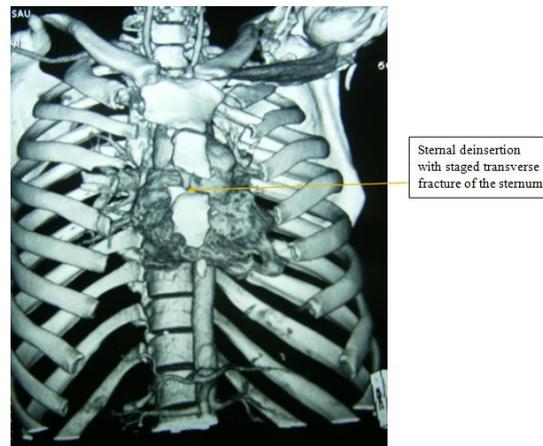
Thoracic CT scan showing sternal deinsertion with staged transverse fracture of the sternum
